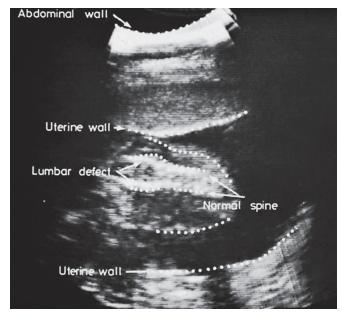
Ultrasound showing lumbar spine defect.
